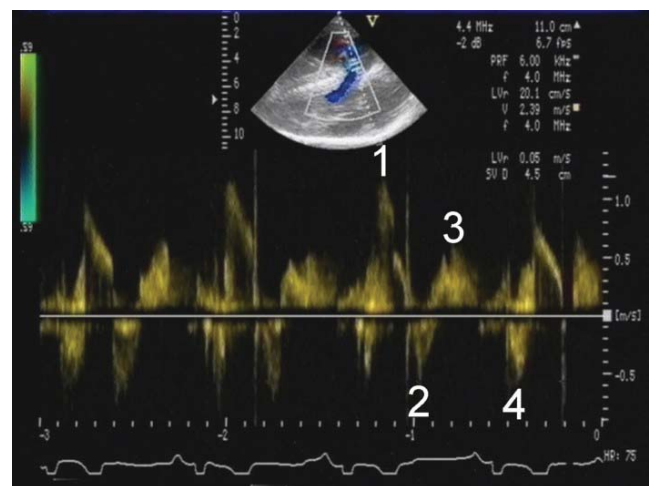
Right parasternal long-axis view. Spectral Doppler representation of the flow and shunting situation at the site of the VSD below the aortic valve. No angle correction used. 1 = systolic outflow, 2 = early diastolic right to left shunt (represented also in the small 2D-image), 3 = diastolic left to right shunt, 4 = turbulent early systolic flow.
